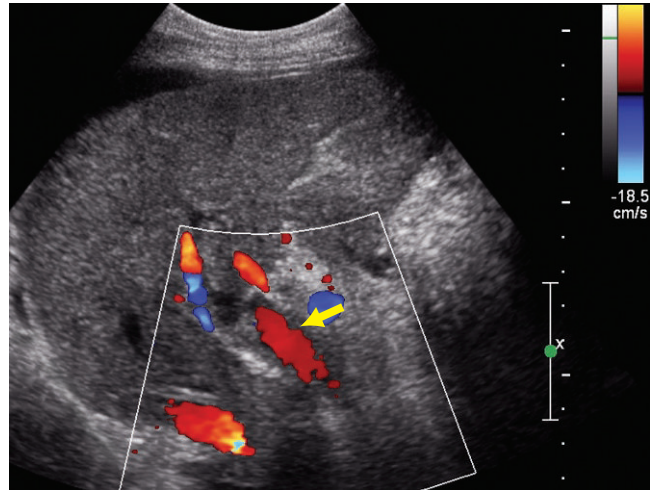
The color Doppler sonographic image of the liver shows color Doppler flow (arrow) around the isoechoic thrombus indicating that it is non-occlusive.
